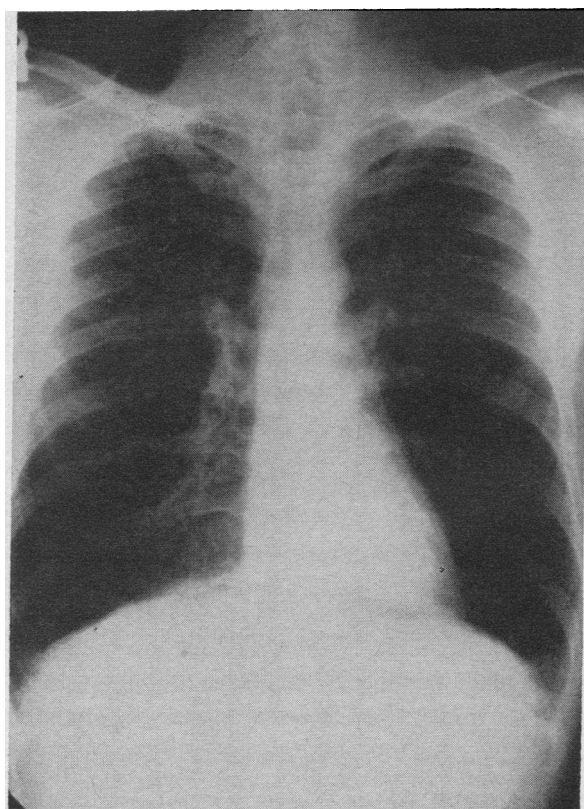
CHEST FILM IN PATIENT 2. The plain film shows only flattening of the diaphragms and increased radiolucency of both lung fields.
